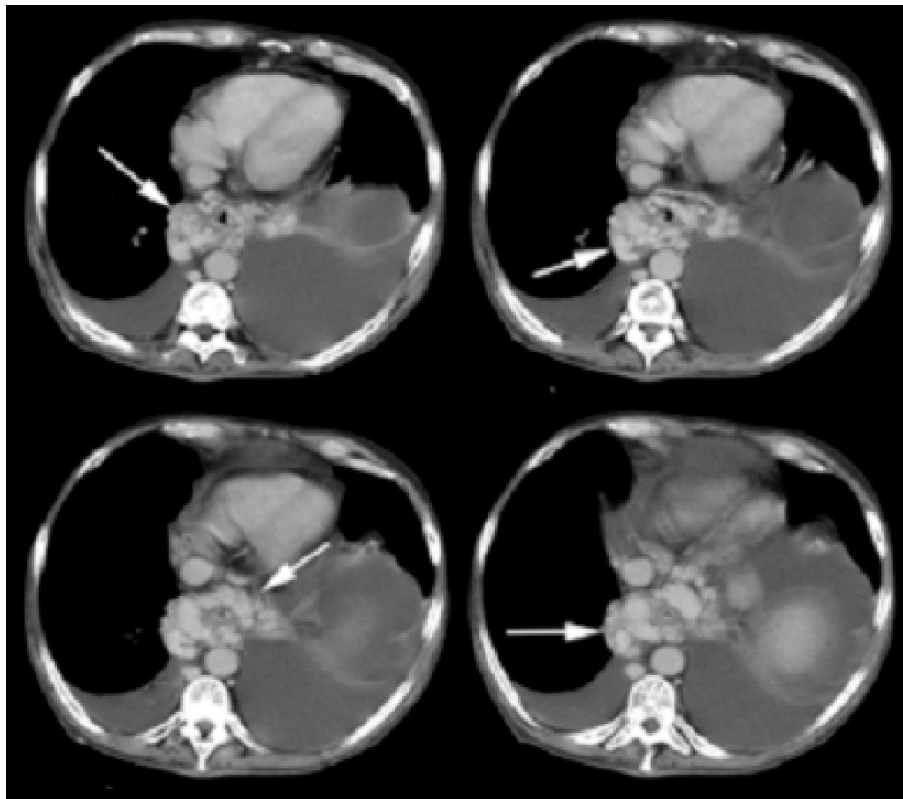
Axial CT images venous phase shows dilated and tortuous esophageal varices (white arrows) ⁽²⁵⁾.
